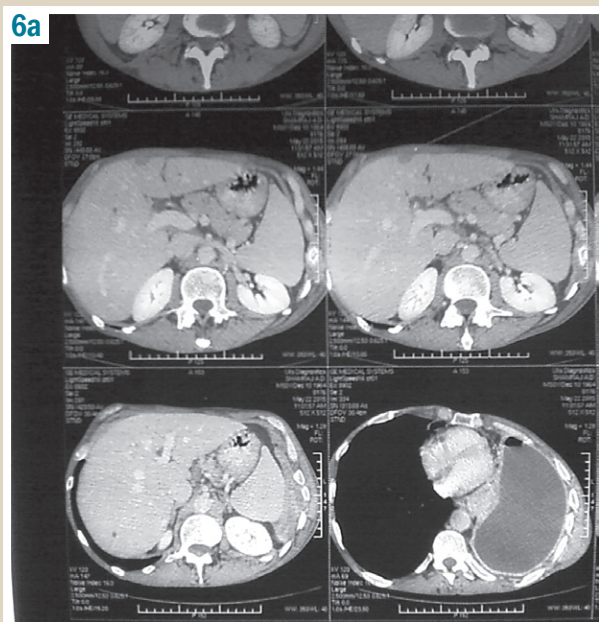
CT AO after 7 months of the maintenance phase of pulmonary MRTB treatment.
